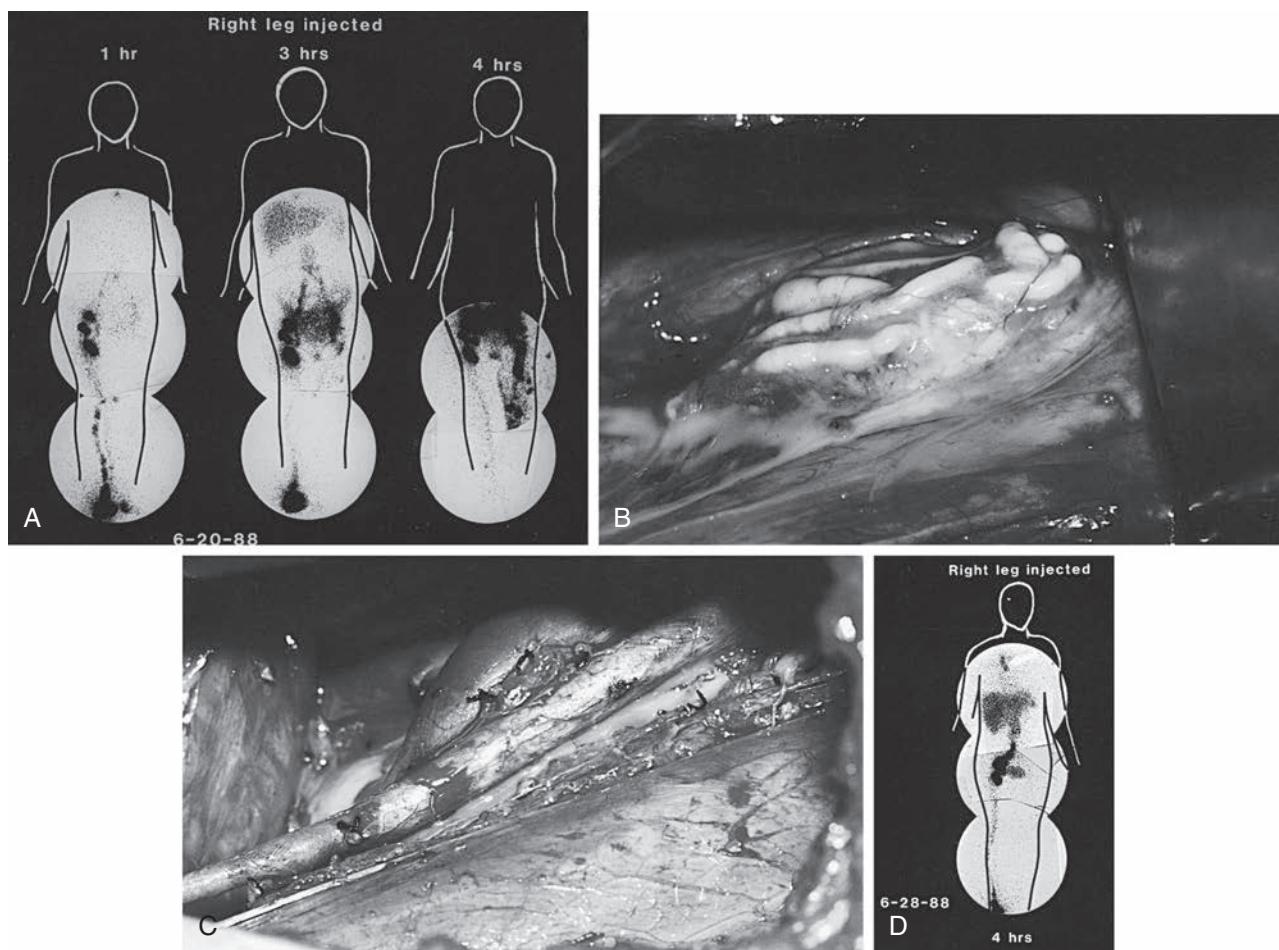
(A) Right lower extremity lymphoscintigram in a 16-year-old girl with lymphangiectasia and severe reflux of chyle into the genitalia and left lower extremity. Injection of the isotope into the right foot reveals reflux into the pelvis at 3 hours and into the left lower extremity at 4 hours. (B) Intraoperative photograph reveals dilated, incompetent retroperitoneal lymphatics in the left iliac fossa containing chyle. (C) Radical excision and ligation of the lymph vessels were performed. In addition, two lymphovenous anastomoses were created between two dilated lymphatics and two lumbar veins. (D) Postoperative lymphoscintigram reveals no evidence of reflux at 4 hours. The patient has no significant reflux 4 years after surgery. (From Gloviczki P, Calcagno D, Schirger A, et al. Noninvasive evaluation of the swollen extremity: experiences with 190 lymphoscintigraphic examinations. *J Vasc Surg*. 1989;9:683.)
